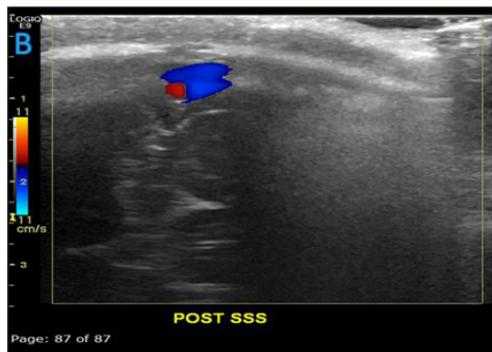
Average caliber of posterior segment of superior sagittal sinus with optimum color Doppler flow.
